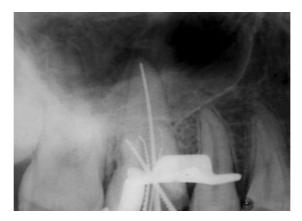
In the radiograph taken to determine working length, the C-shaped canal in the buccal root appeared to have three foramina; the palatal root had a single wide canal.
